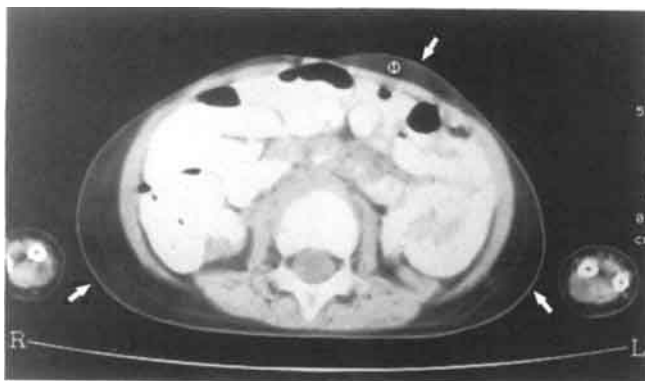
MRI scan of abdomen. Fat deposition in flanks and left upper quadrant indicated by arrows.
